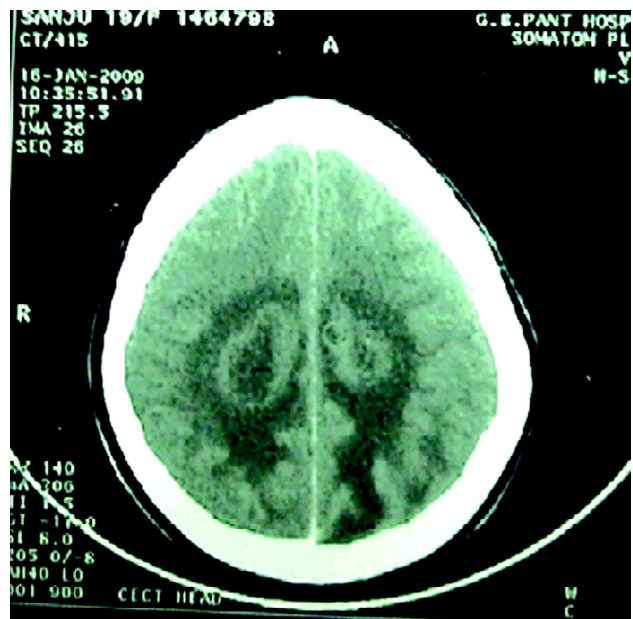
Follow-up CT scan head (16/01/09) – Post-contrast axial image showing bilateral, large, parasagittal ring-enhancing lesions with surrounding oedema (with significant resolution of the earlier lesions).
